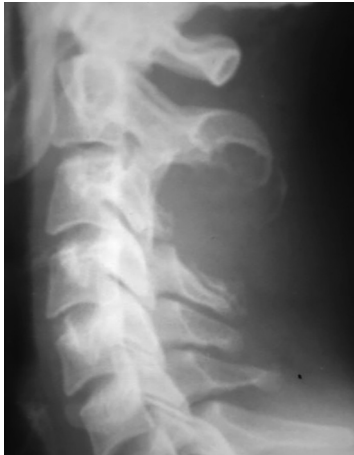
Plain radiograph of the cervical spine showing destruction of the C3 lamina and erosion of the adjacent C2 and C4 lamina by an osteolytic mass
